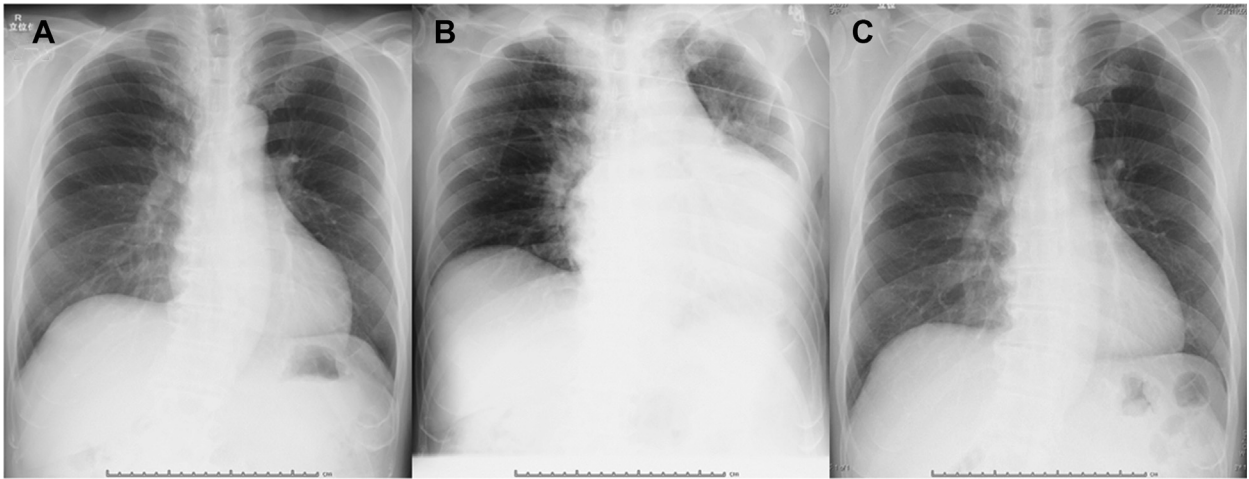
A, B: Chest radiographs taken 29 days (A) and 95 days (B) after the procedure. C: Chest radiograph taken 1 month after pericardiocentesis.
